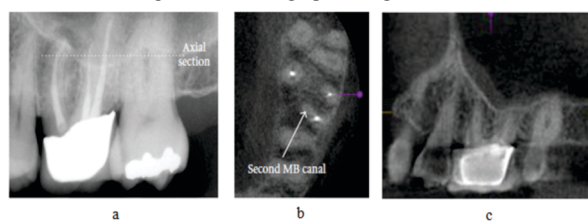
(a). Note the overlap of the interproximal contacts between the molars indicating a geometric distortion in the horizontal plane. CBCT imaging ((b) 0.076mm axial and (c) 0.076 Parasagittal) clearly demonstrates an additional canal that was not previously treated.
